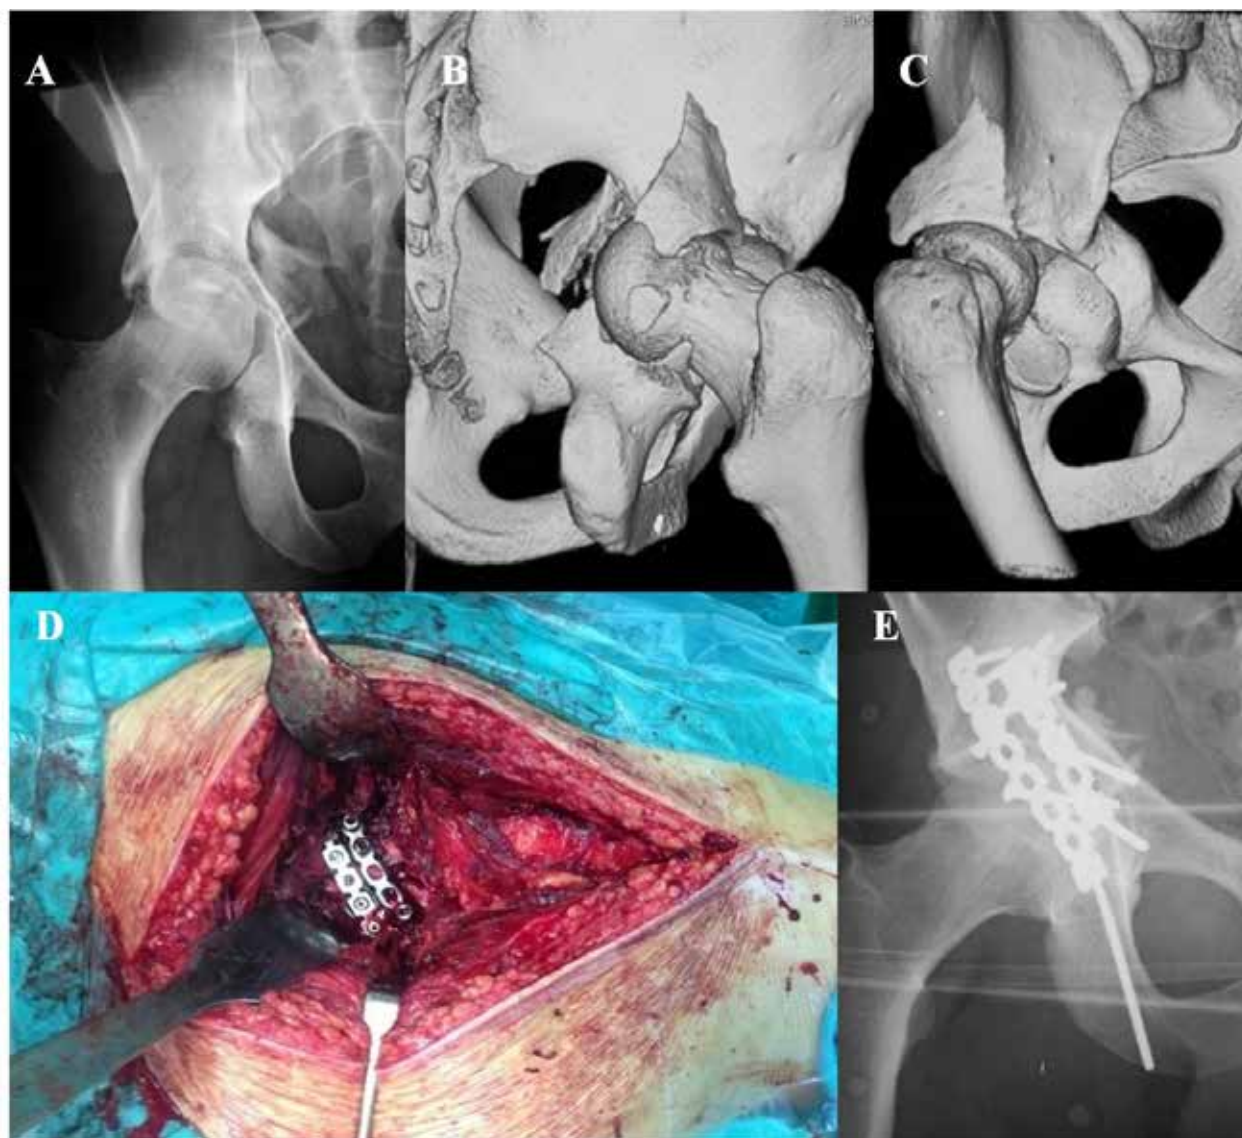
Transverse acetabular fractures associated with posterior wall fracture- dislocation of the acetabulum. A- X- ray after the injury; B,C- 3D- CT; D- Intraoperative appearance ; E- X-ray after the open reduction and internal fixation.
